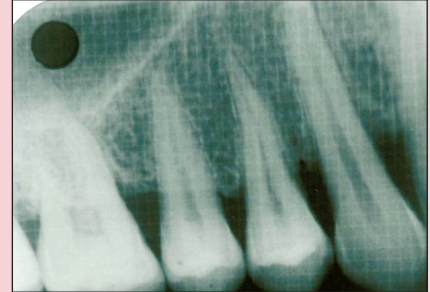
Postoperative radiograph of the test site at 6 months.
